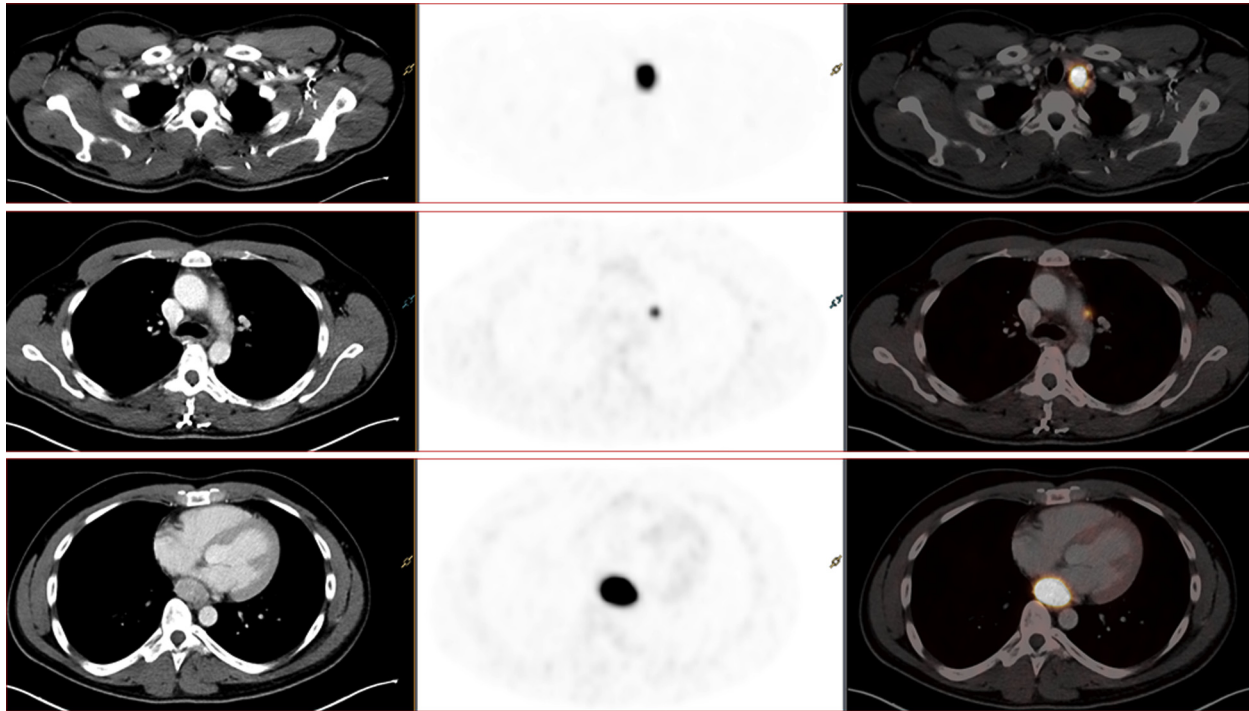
Gallium Ga 68-DOTATATE positron emission tomographic (PET) computed tomographic (CT) scan (axial plane) of the patient presenting the paragangliomas located next to the left carotid artery, aortopulmonary window, and posterior to the left cardiac atrium. (Left column, CT scan; middle column, attenuation corrected PET image; right column, PET-CT fused.)
